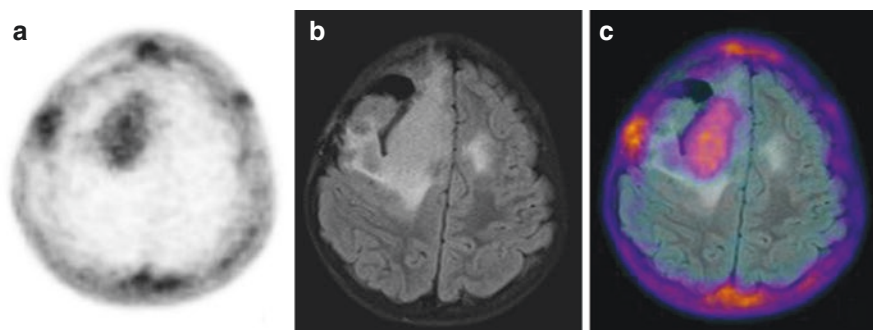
(a) PET, (b) MRI, (c) Fused. High ^{18}F CH uptake in a the large GBM of the left frontal lobe
